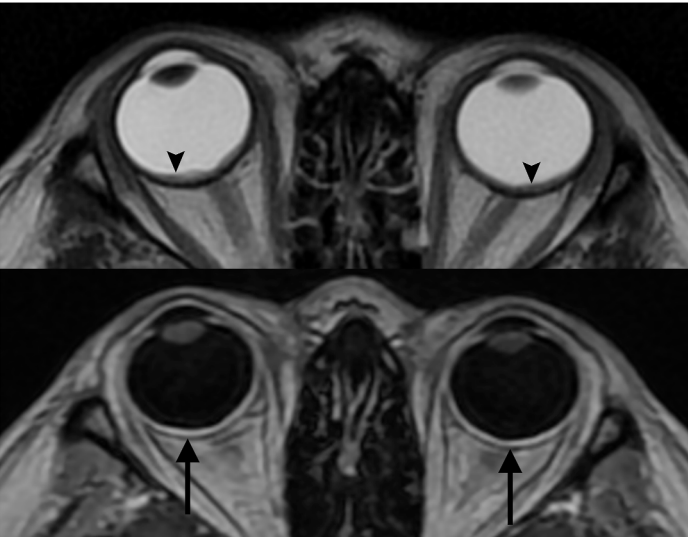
Axial T2-weighted (top) and gadolinium-enhanced T1-weighted (bottom) MR sequences of the orbits demonstrating uveitis with bilateral uveal thickening and enhancement (black arrows) and subretinal fluid (black arrowheads) in a known case of Vogt-Koyanagi-Harada (VKH) disease.
